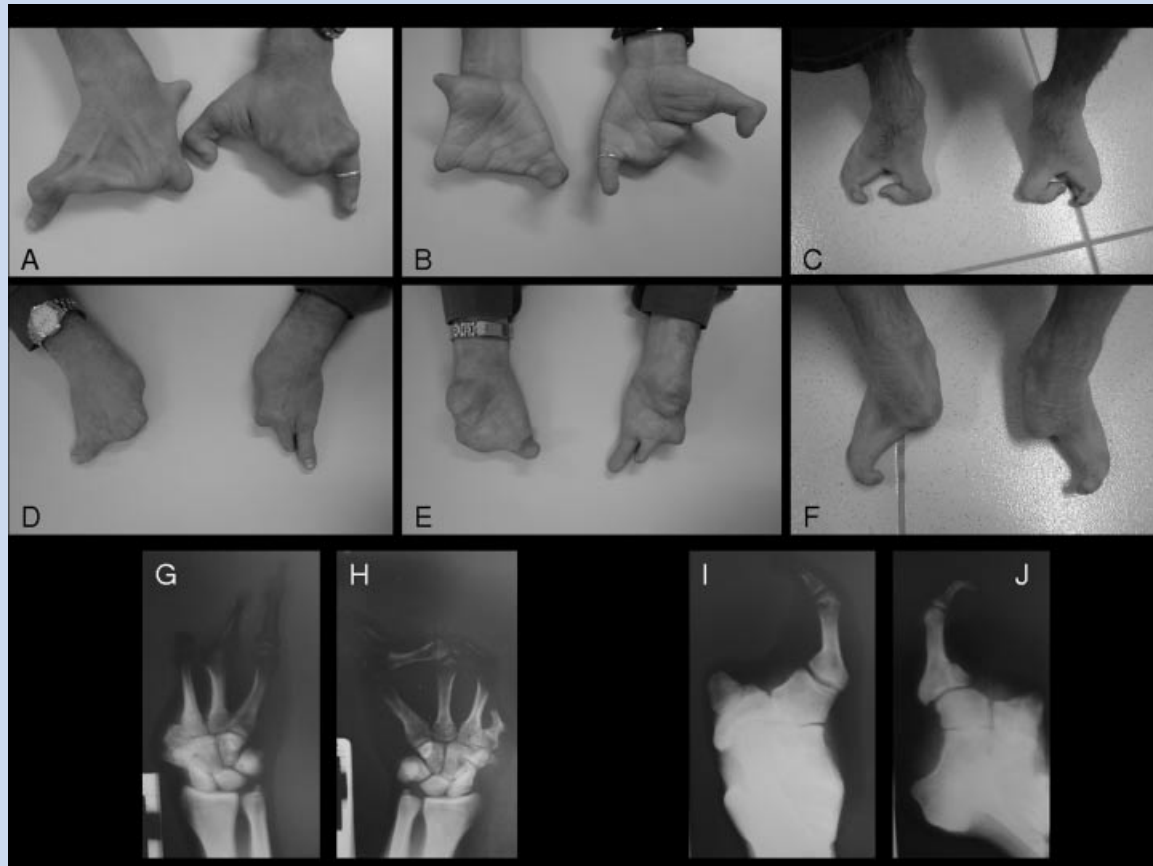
Patient 1. A: Truncations of all II–IV phalanges bilaterally, rudimentary thumb, and transverse phalanx IV–V on the right hand, both 5th rays appear normal, metacarpals I–IV of both hands are shorter and malformed, no long bones deficiencies of the zeugopod. B: Smooth palmar creases with abnormal pattern, hypoplastic thenar/hypothenar. C: Classical bidactylous SHFM. Patient 2. D: Terminal truncations of the upper limbs causing monodactylous ectrodactyly/oligodactyly of both hands. E: Smooth palmar creases with abnormal pattern, hypoplastic thenar/hypothenar. F: Monodactylous ectrodactyly of both feet, only the 5th ray is present. G: X-ray, bidactyly of left hand. H: X-ray, monodactyly of right hand. I: X-ray, monodactyly of left foot. J: X-ray, monodactyly of right foot.
